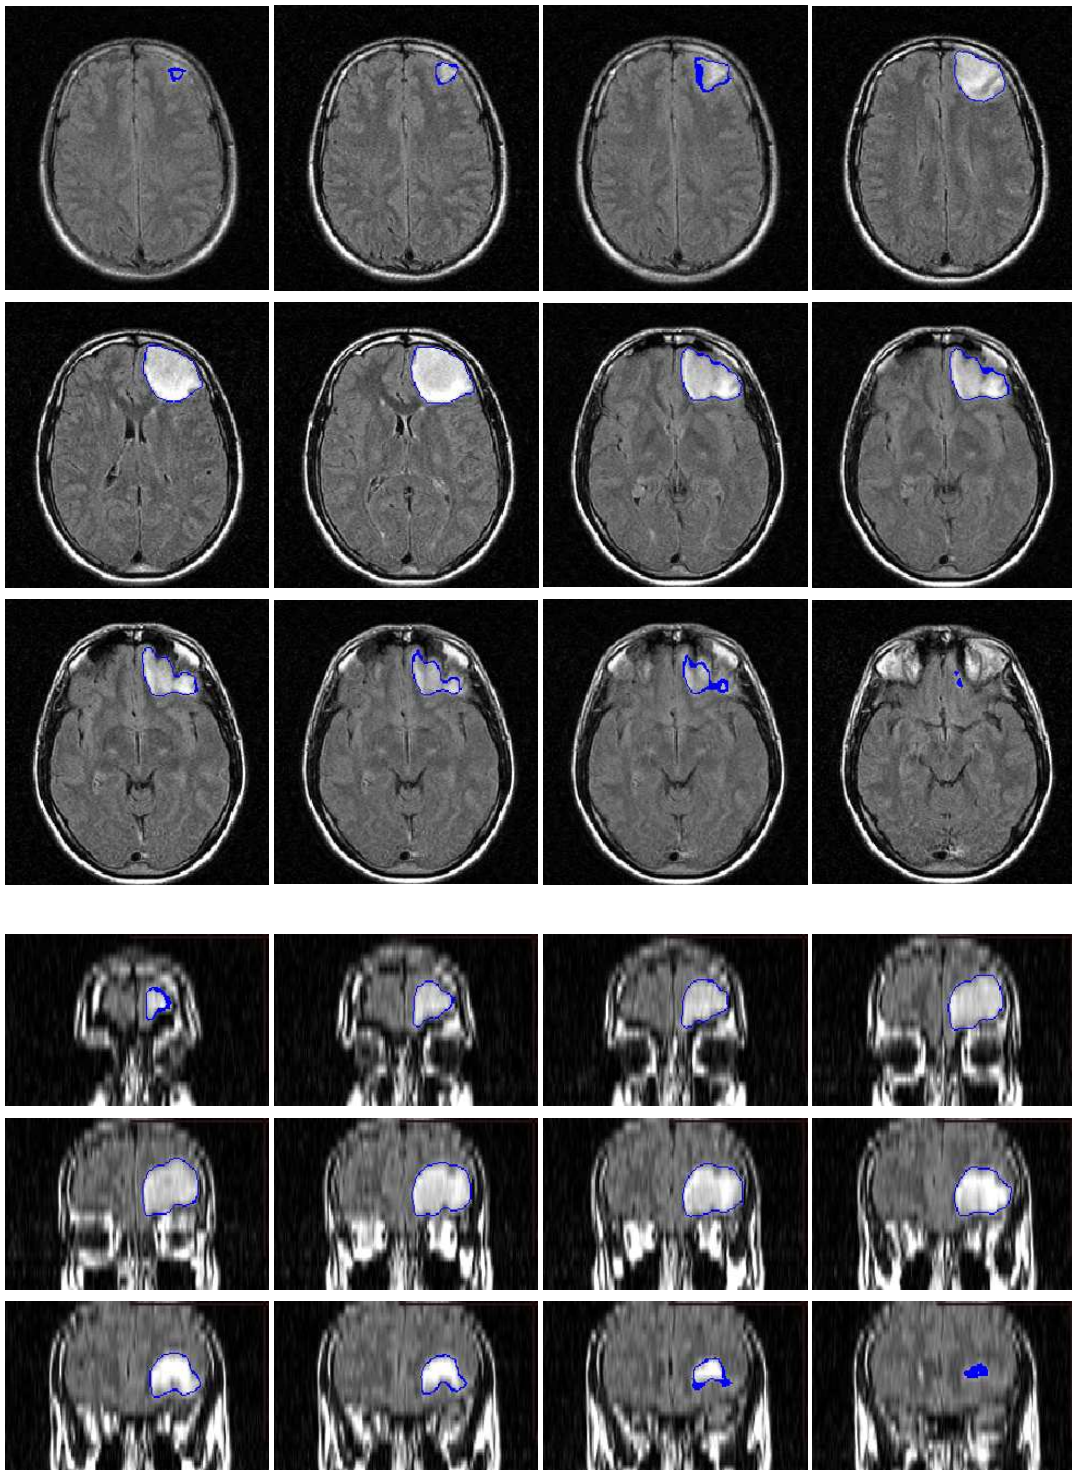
Axial and coronal slices of a segmented tumor in a FLAIR image by symmetry analysis and deformable model constrained by spatial relations.
